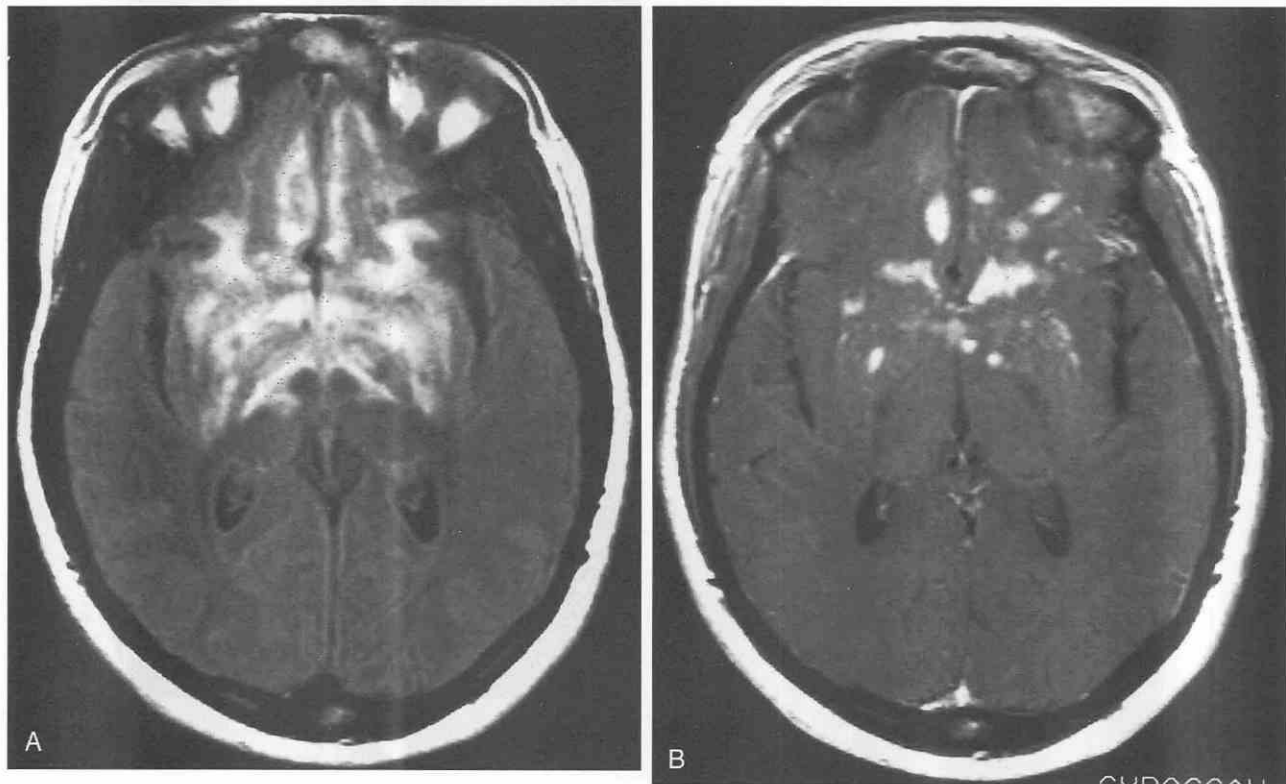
Sarcoidosis. A, Fluid-attenuating inversion recovery (FLAIR) image shows diffuse, irregular, abnormal high signal intensity extending from the subarachnoid space into the brain parenchyma of frontal lobes and basal ganglia. B, Gadolinium-enhanced image demonstrates patchy contrast enhancement involving the frontal lobes and basal ganglia.
